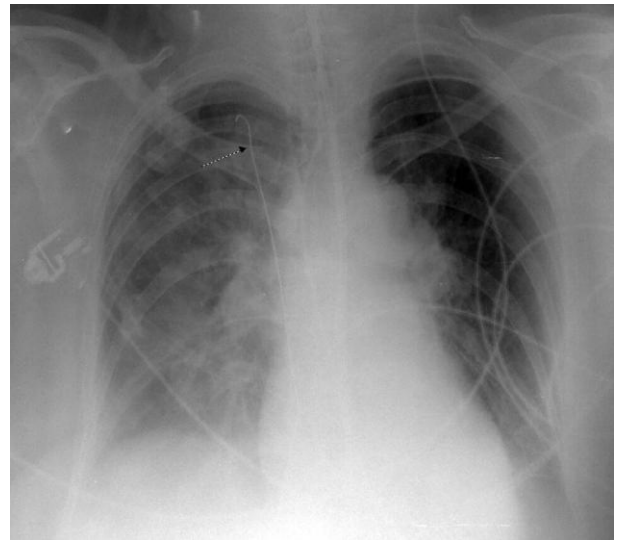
PA chest radiograph demonstrating an embolized guide wire (arrow) from an attempt at femoral venous line access. Note that the tip of the wire is projecting in expected location of superior vena cava.
